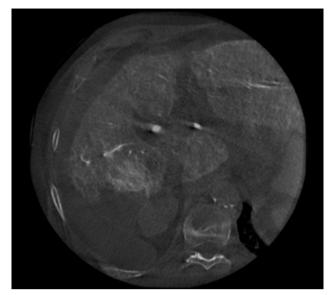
Dual-phase cone beam CT confirmed the lesion – Arterial phase 3 mm MPR
